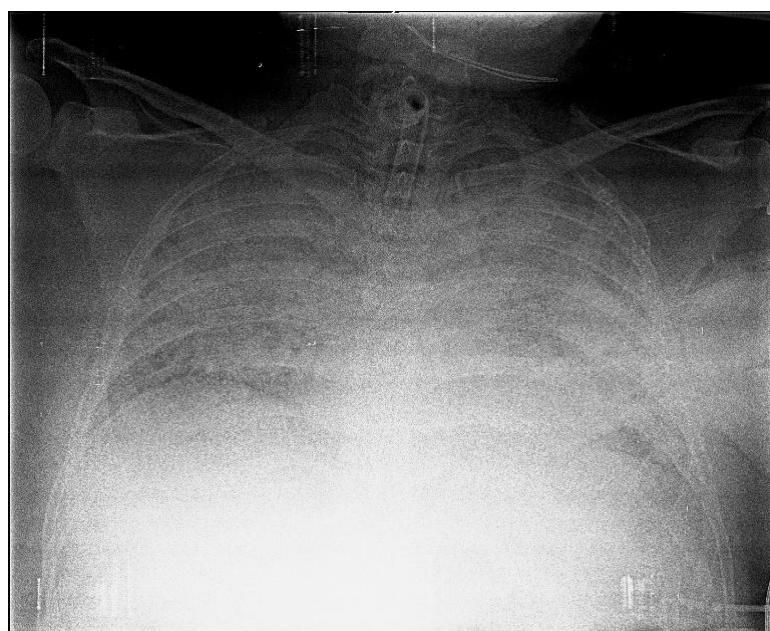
Chest x-ray showing severe pulmonary edema
